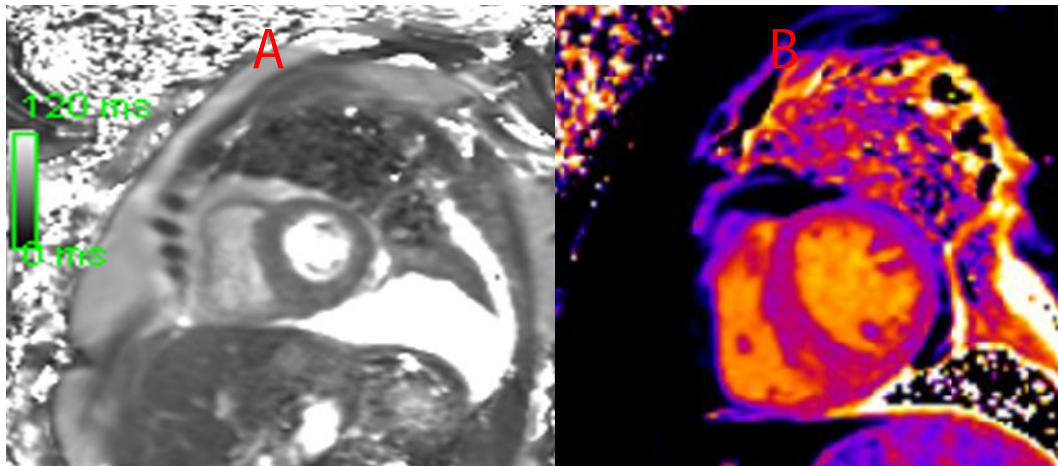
Cardiac MRI: A- T2 mapping: showing hypertrophy of the left ventricle and fibrose diffuse epicardial. B- T1 mapping showing hypertrophy of the left ventricle more important at the septum with diminution gadolinium due to fibrose developpment en favor of amyloidosis.
